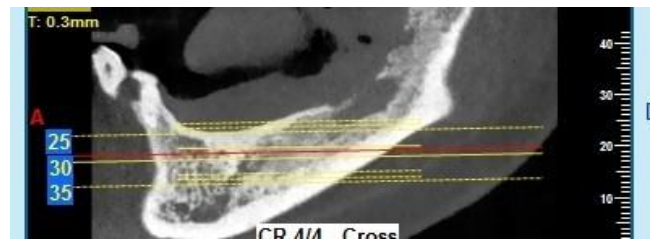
These CBCT images depict the mental foramen and inferior alveolar nerve canal involvement.
